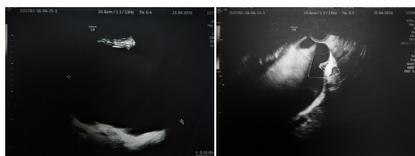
Two ultrasound images showing a voluminous image of cystic tone with an endocystic vascularized Doppler bud.
